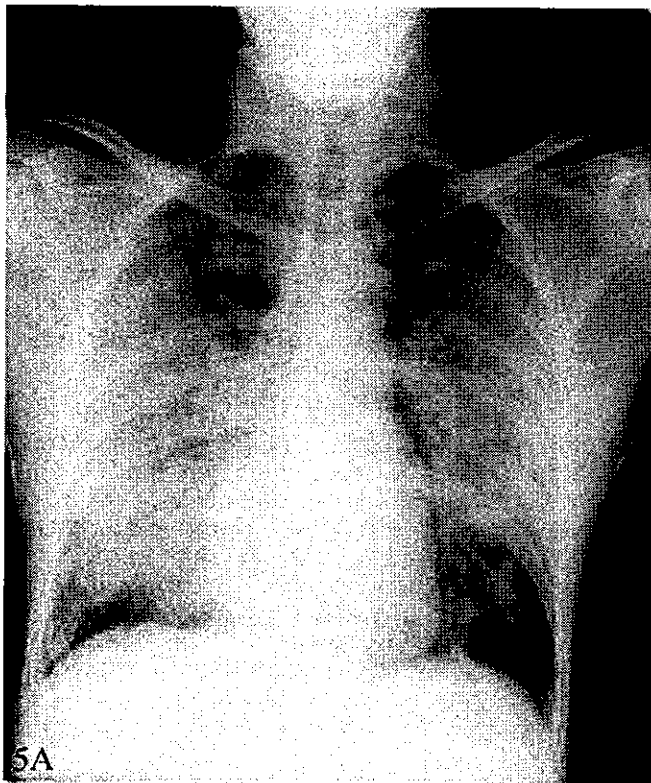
Chest radiographs in severe acute respiratory syndrome (SARS) and non-SARS. A, Chest radiograph in more advanced stages of a SARS coronavirus infection showing bilateral, diffuse, ground-glass shadowing with consolidation at the periphery of both lungs. B, Chest radiograph from a non-SARS case showing lobar consolidation involving the right upper and lower lobes with air bronchograms. A focus of consolidation is seen at the left middle zone.
